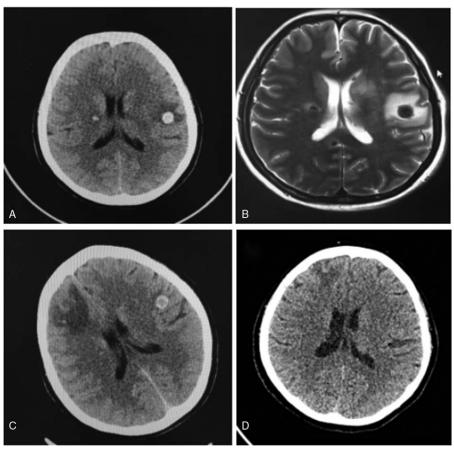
The imaging findings of this patient. (A) Many quasi-circular high density nodes on both cerebral hemispheres can be seen using brain computed tomography (CT). (B) Brain magnetic resonance images (MRI) (plain and enhance scan) revealed multiple lesions in the brain. (C) Brain MRI showed the nodes were low density inside whereas high density outside. (D) Brain CT examined on October 18th 2016 showed that focal intracerebral hemorrhage was absorbed. CT= computed tomography, MRI = magnetic resonance images.
